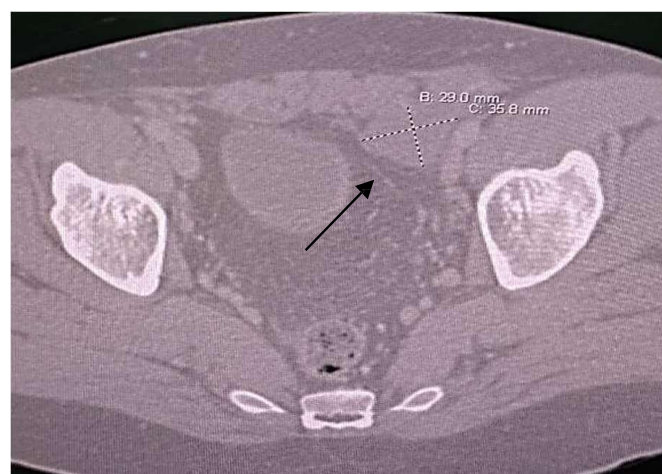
CT scan of pelvic revealing left testicle located proximal to left inguinal canal [At tip of arrow].
